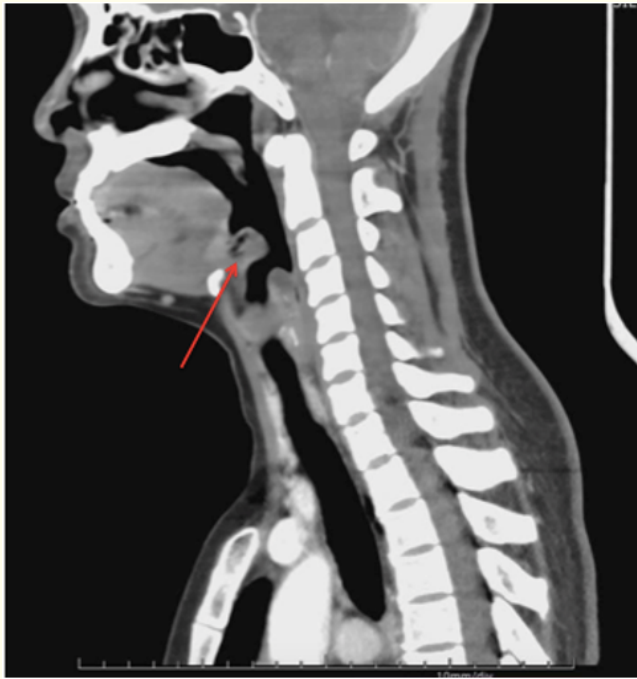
Sagittal view of computed tomography (CT) of neck with intravenous contrast shows epiglottic swelling (red arrow).
